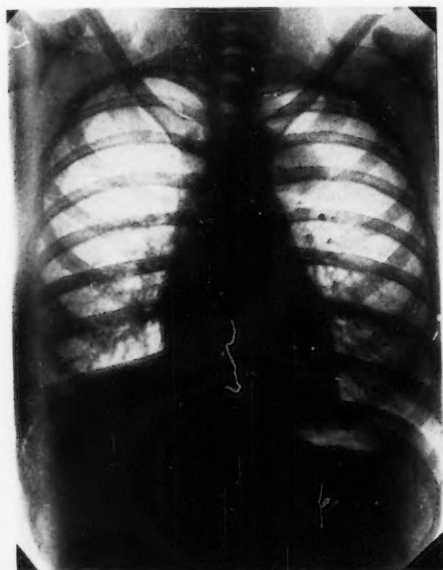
X-ray film made July 4, 1947. A rounded shadow is seen just outside and to the left of the aortic arch.
